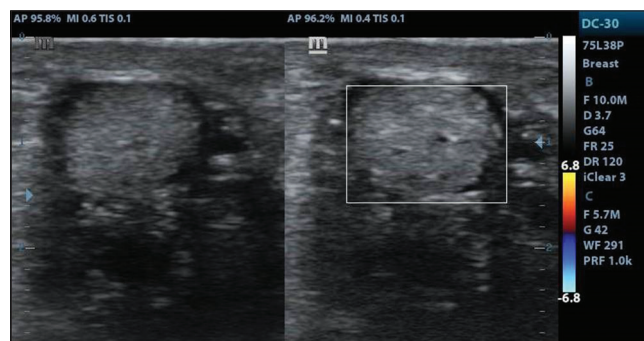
US image shows a well-circumscribed, homogenous, isoechoic, lesion with no blood vessels inside it on Color Doppler, suggestive of benign lesion. CNB revealed benign breast lipoma
